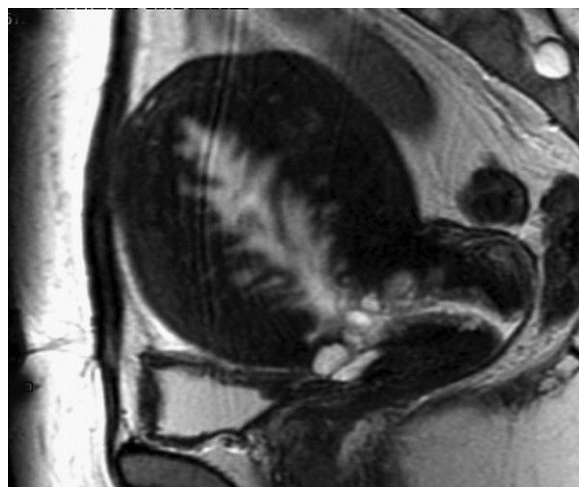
Sagittal T2-weighted FSE image depicts an enlarged uterus with diffuse adenomyosis. There is diffuse thickening of the junctional zone, and high signal intensity fluid-filled glands are seen to extend from the endometrium.
